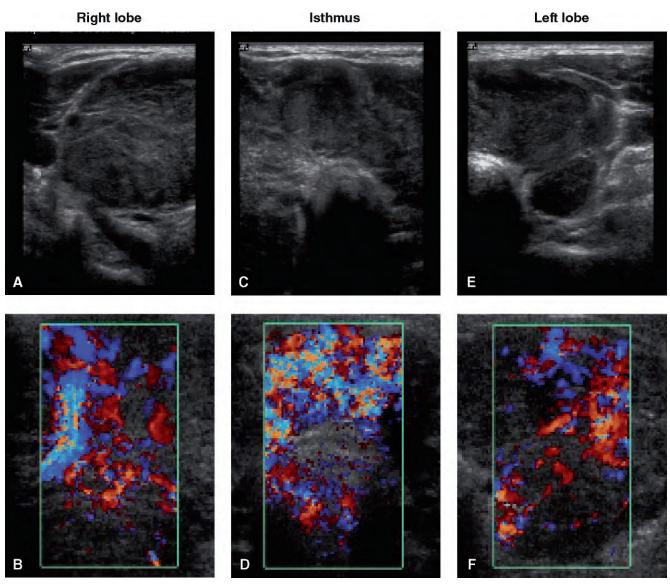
Ultrasound of thyroiditis in both lobes. A, Right lobe. B, Color Doppler, right lobe. C, Isthmus. D, Color Doppler, isthmus. E, Left lobe. F, Color Doppler, left lobe.
